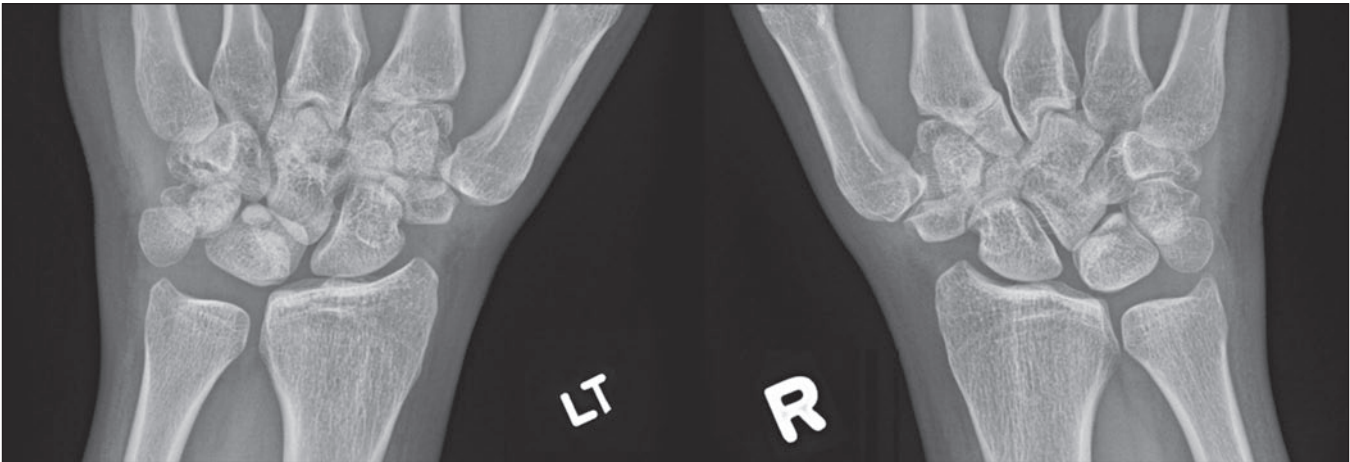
Plain radiographs of bilateral wrists. LT Left; R Right
